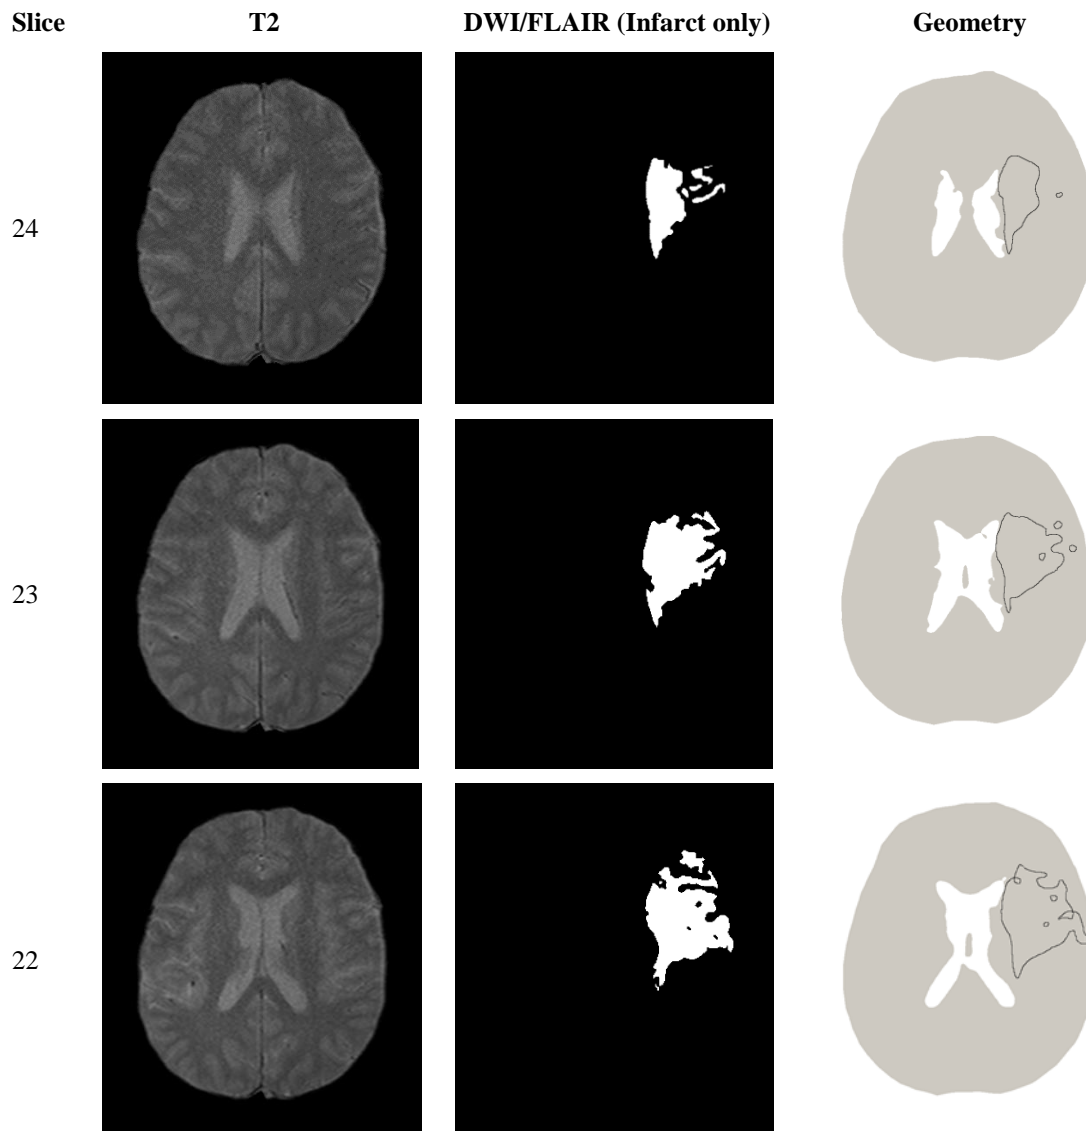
The MRI images and geometry of slices 22 to 24 of patient 1.
